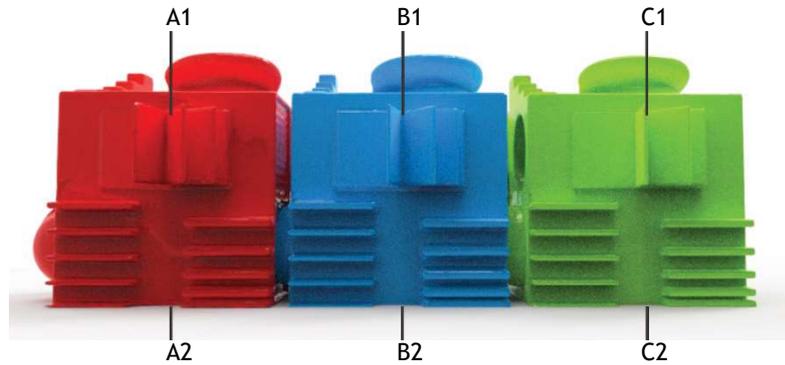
CT results of Angulation Test Features: 3D Doctor® (A1), Mimics® (B1), Invesalius® (C1), Spacing and Distance Test Features: 3D Doctor® (A2), Mimics® (B2), Invesalius® (C2).
